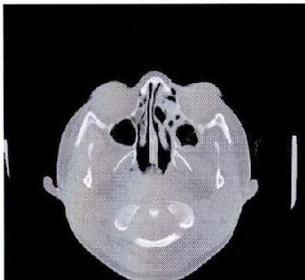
CT scan of the para nasal sinuses 4 months on itraconazole showed interval improvement.
